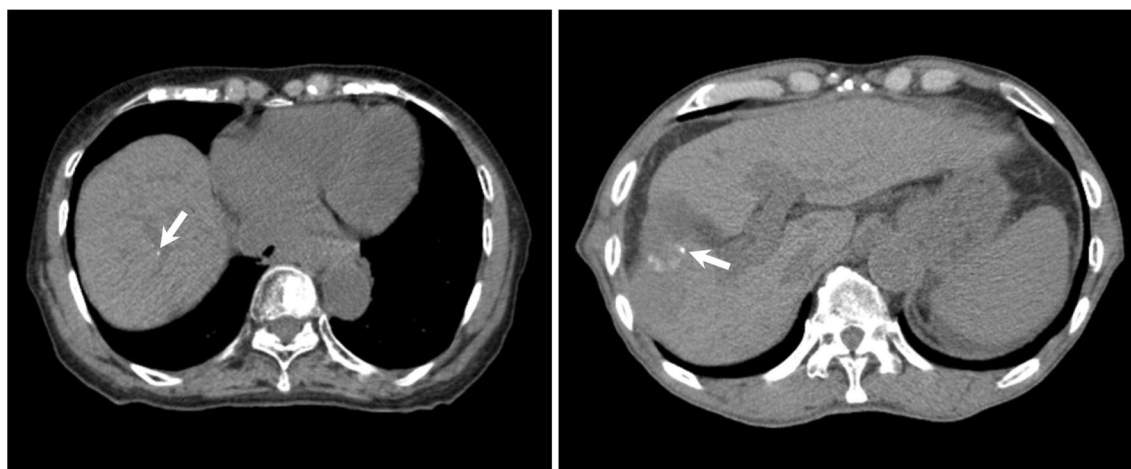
Examples of evaluation points in CT images. Left: calcification, right: Lipiodol
